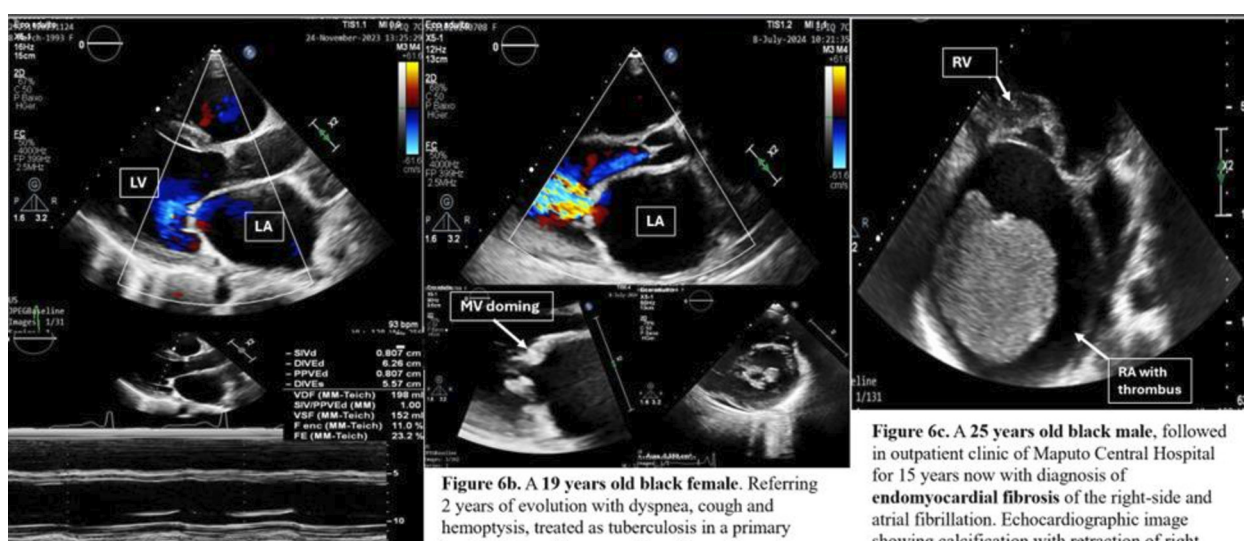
A 30 years old female admitted with congestive heart failure 3 months after delivery. Diagnosed with peripartum cardiomyopathy. Echocardiographic images showing dilated left atrium (LA) and ventricle (LV) with severe LV dysfunction (Ejection fraction estimated in 23%).
